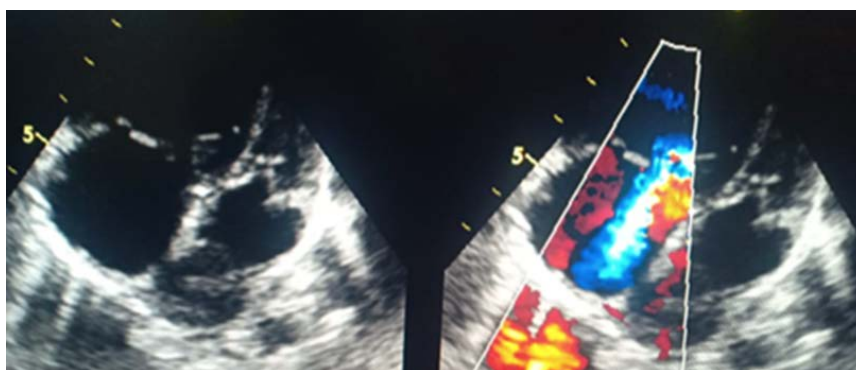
Transthoracic echocardiography: apical section with color doppler showing a flow of pulmonary insufficiency with dilation of the right cavities
